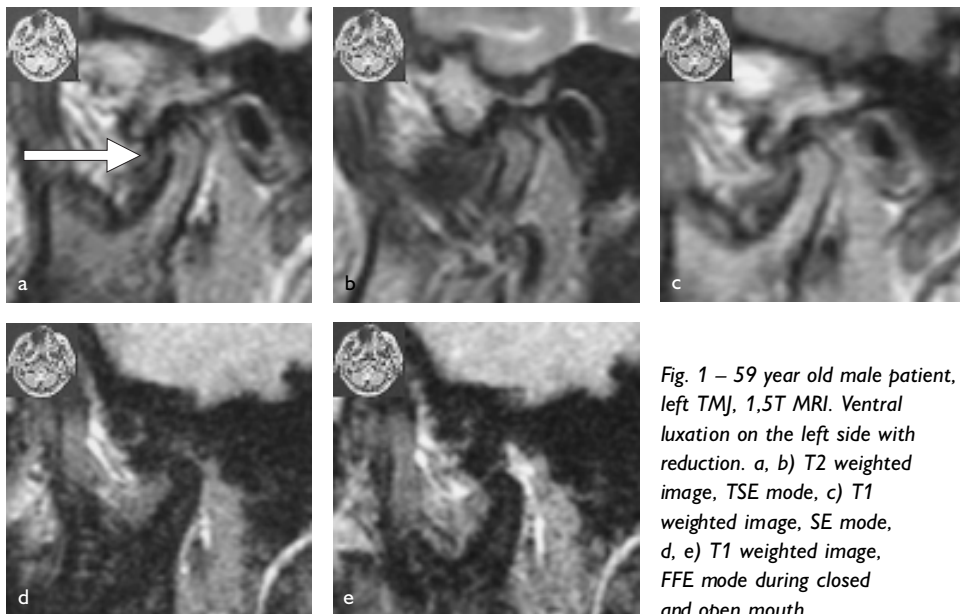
59 year old male patient, left TMJ, 1,5T MRI. Ventral luxation on the left side with reduction. a, b) T2 weighted image, TSE mode, c) T1 weighted image, SE mode, d, e) T1 weighted image, FFE mode during closed and open mouth.
